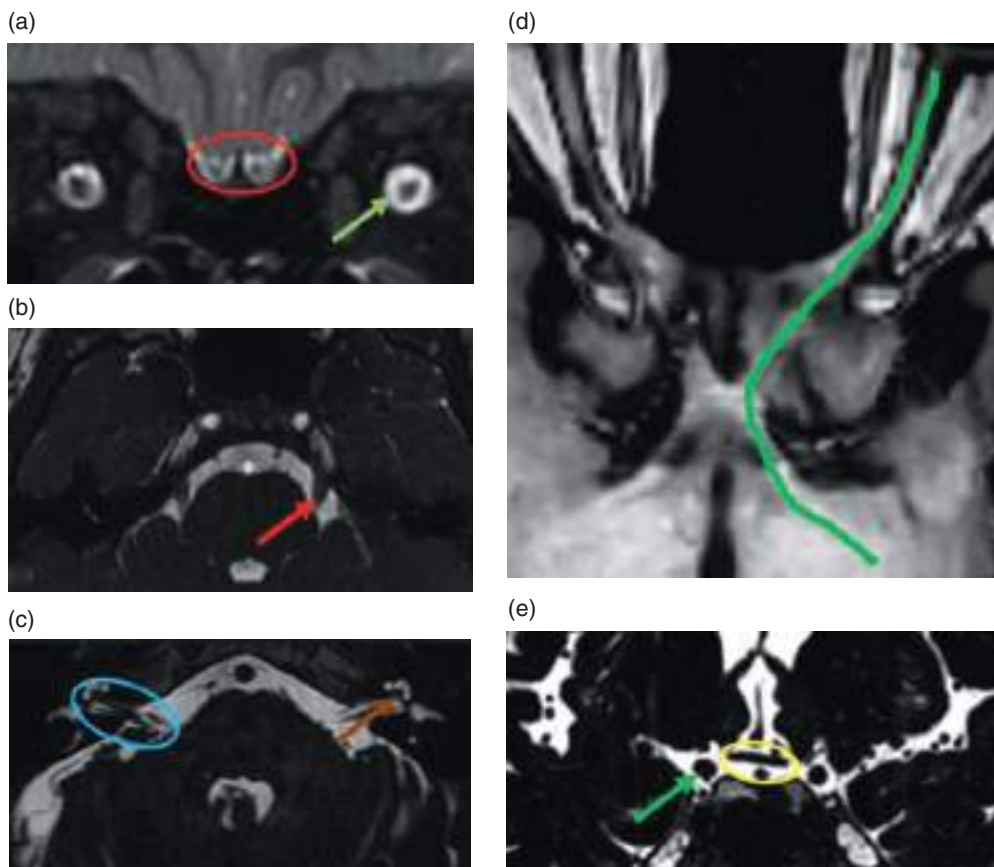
Basic anatomy of the cranial nerves. (a, b, c, e) High-resolution 3D DRIVE T2-weighted MRI. (d, e) Oblique axial T1-3D-weighted MRI. (a) Coronal image showing the olfactory nerve in the olfactory groove (red circle) and the optic nerve in its intraorbital segment (green arrow). (b) Axial image showing the trigeminal nerves (red arrow) reaching the Meckel's cave. (c) Axial image showing the cisternal segments (cerebellopontine angle) and intracanalicular segments of statoacoustic and facial nerve bundles (blue circle). The arrival of the cochlear nerves (branch of the VIII cranial nerve) at the cochlea can be appreciated (brown arrow). (d) Axial imaging showing the orbital, cisternal, and chiasmatic segments, and optic tracts of the II cranial nerve (green line). (e) Coronal image showing the optic chiasm (yellow circle), medial to the internal carotid arteries (green arrow) and above the sella turcica.
